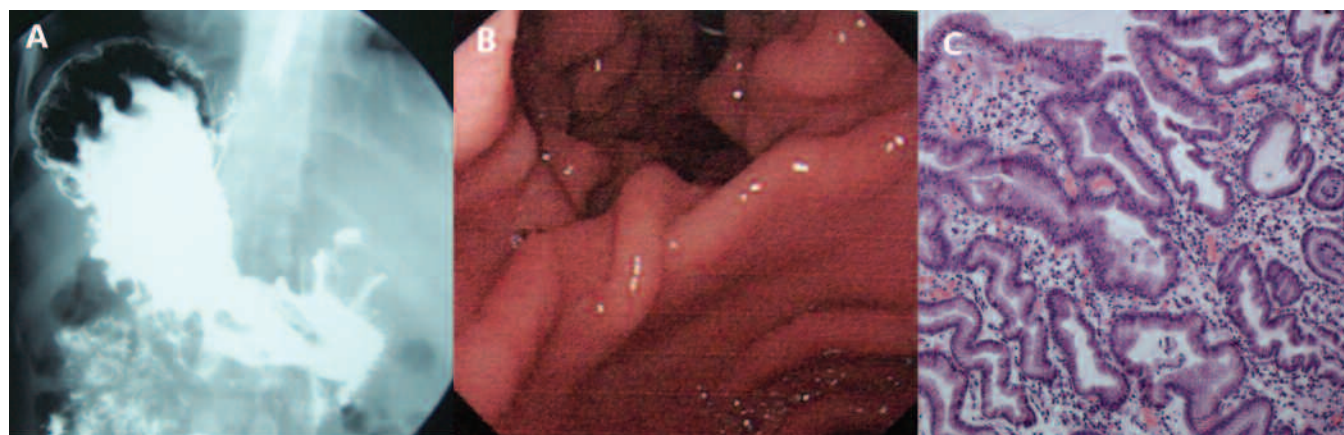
A. Barium radiography; and B. gastroscopy show gyrus-like mucus folds at gastric body and fundus. C. Gastric mucosa biopsy showed mildly enlarged mucosa, with interstitial edema and inflammatory cell infiltration.
